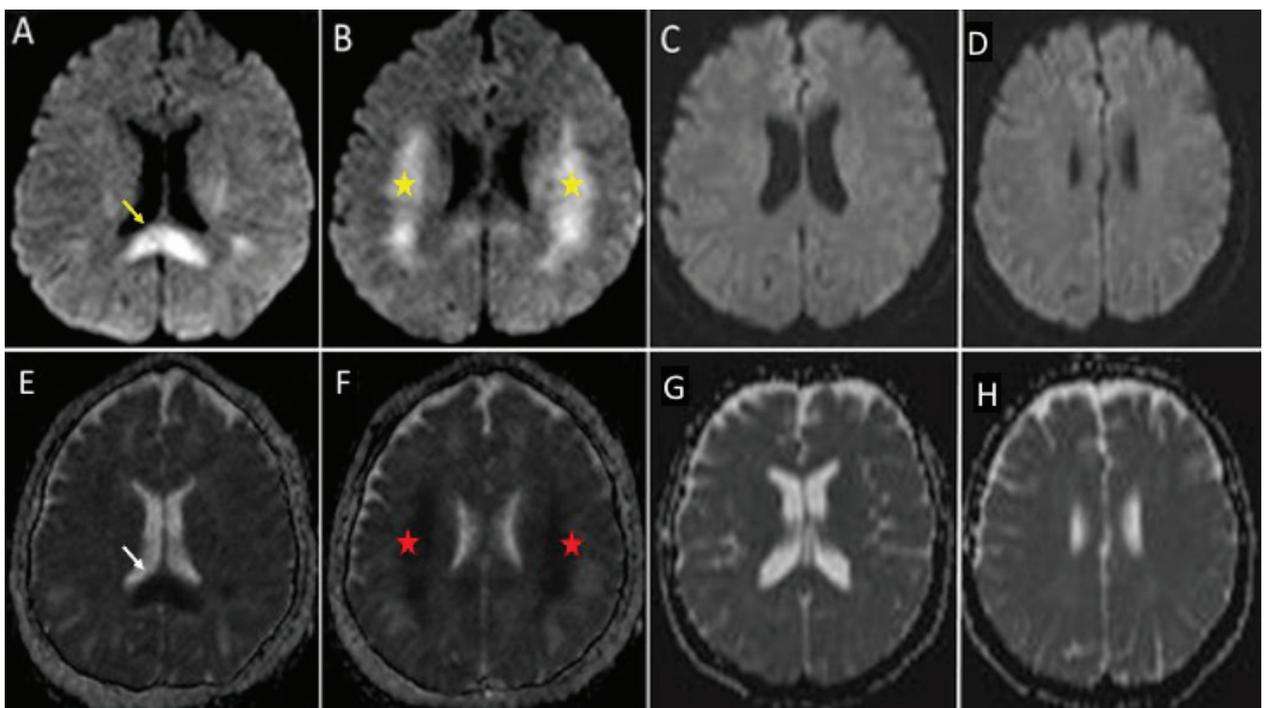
34-year-old female images A) Acute diffusion restriction in the middle part of the splenium (yellow arrow), B) diffusion restriction in the bilateral centrum semiovale (yellow asterisks) C,D) Normalization is seen in the control diffusion images after 20 days, E) ADC map in the splenium (white arrow) indicates low signal intensity on her first MRI and F) indicates low signal intensity in bilateral centrum semiovale (red asterisks), G,H) after 20 days control ADC maps show normalization in splenium and bilateral centrum semiovale
